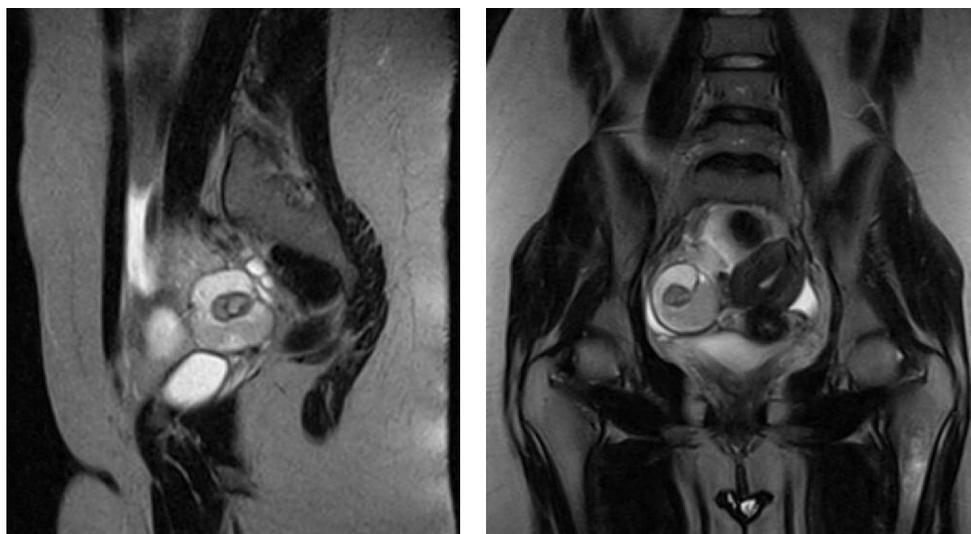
MRI of the pelvis showing right adnexal irregular mass lesion with heterogeneous signal intensity; Metastatic lobular breast carcinoma (Top: Sagittal view; Bottom: Coronal view)
